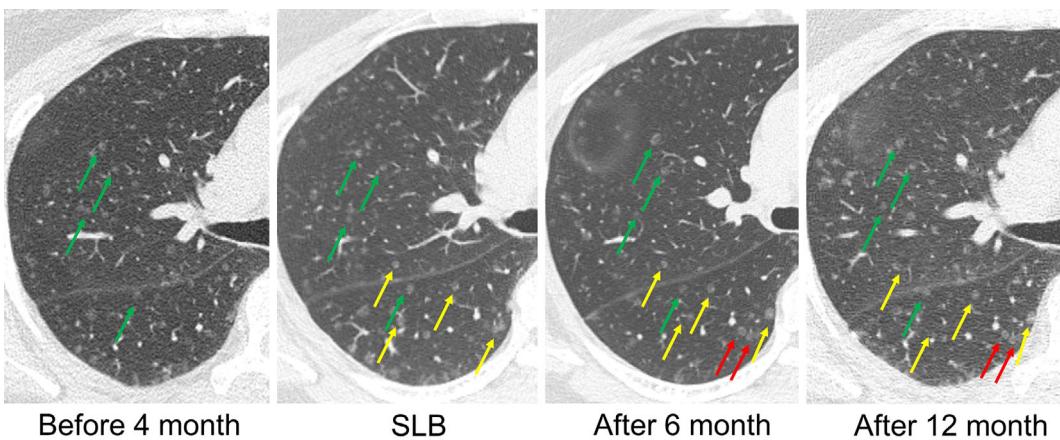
Chest CT confirmed the presence of minute nodules four months prior to a surgical lung biopsy (SLB; green arrows). At the time of the SLB, an increased number (yellow arrows) and slight enlargement of some nodules (green arrows) were observed. Six months after the SLB, the size of the nodules remained unchanged (green and yellow arrows), but the number of nodules increased (red arrows). Twelve months after the SLB, there was no marked increase in the number or size of nodules (green, yellow and red arrows).
